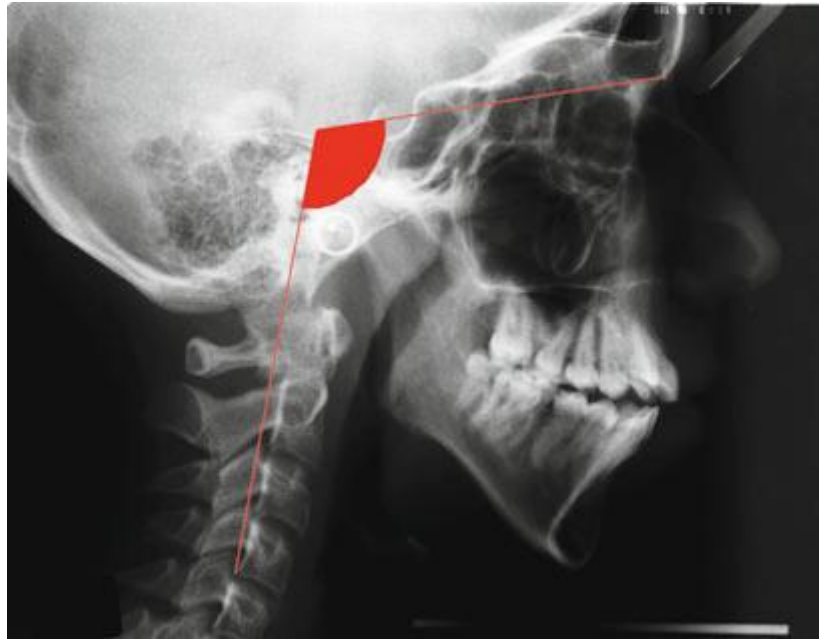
Lateral cephalometric radiograph of mouth breathing patient Pinto, J.A. (2009)
